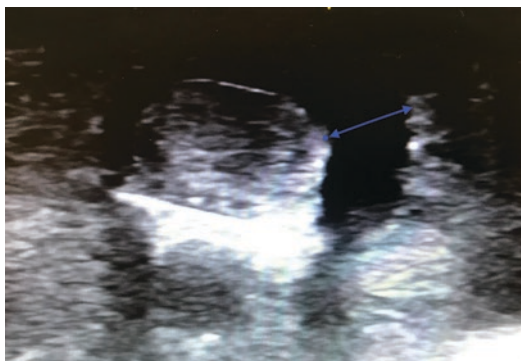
“Halo” phenomenon in the ultrasound (the arrow shows the thickened tendon sheath)
